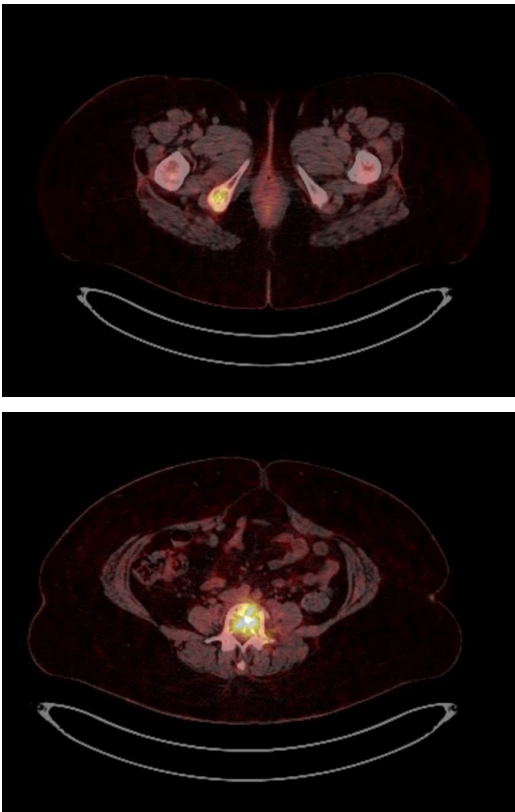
PET scan showing increased FDG uptake in pelvic bone disease, indicating disease progression, October 2025.
